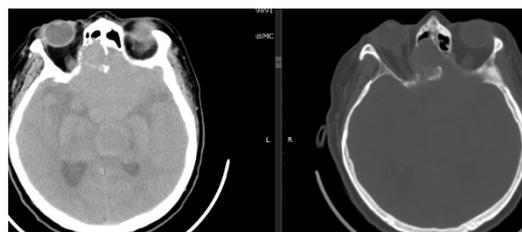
non-contrast CT scan -giant tumor with right ethmoidal cells infiltration
